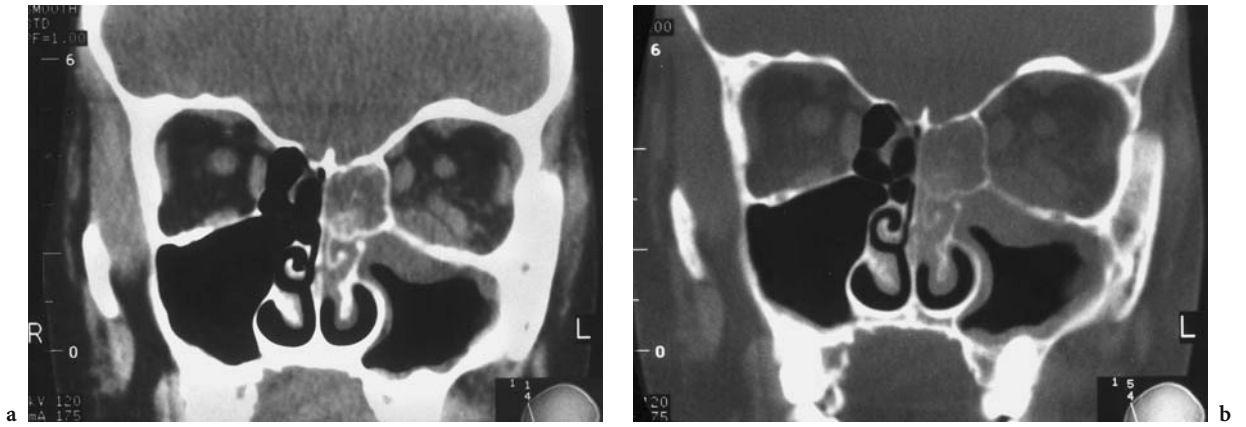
A 10-year-old girl with pansinusitis and reddish swelling of the left cheek, showing a hypomobility of the left eye and fever. Diagnosis: orbital complication of phlegmonous ethmoidal sinusitis. CT: a Coronal view showing subperiosteal extension of the process and bone destruction to the left inferior orbit. b Corresponding bone window
